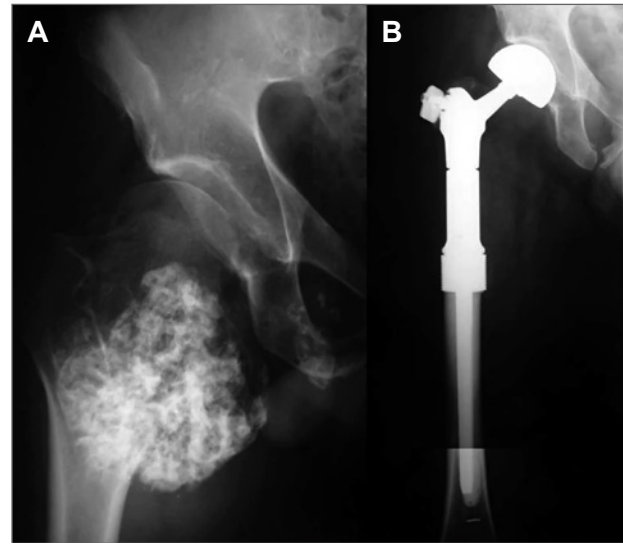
A: Radiograph of the right hip of a 45-year-old man with a grade 2 chondrosarcoma of the proximal femur (Patient 9). B: *En bloc* tumor resection and reconstruction with a bipolar proximal femoral megaprosthesis was done; 28 months postoperatively, the patient is alive with no evidence of local recurrence or distant metastases.
